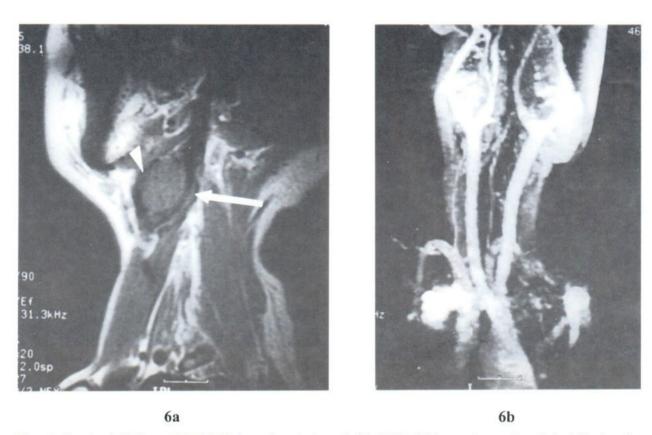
Sagittal Oblique T1W MR imaging (a.) and 2d TOF MR angiography (b.): Nicely shown splaying of the carotid bifurcation, ECA (arrowhead) and ICA (arrow) in (a.)
